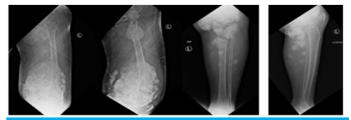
Xray of thigh AP-Lat and leg AP-Lat, showing partially calcified mass with numerous lobulations without any definite evidence of bone destruction
